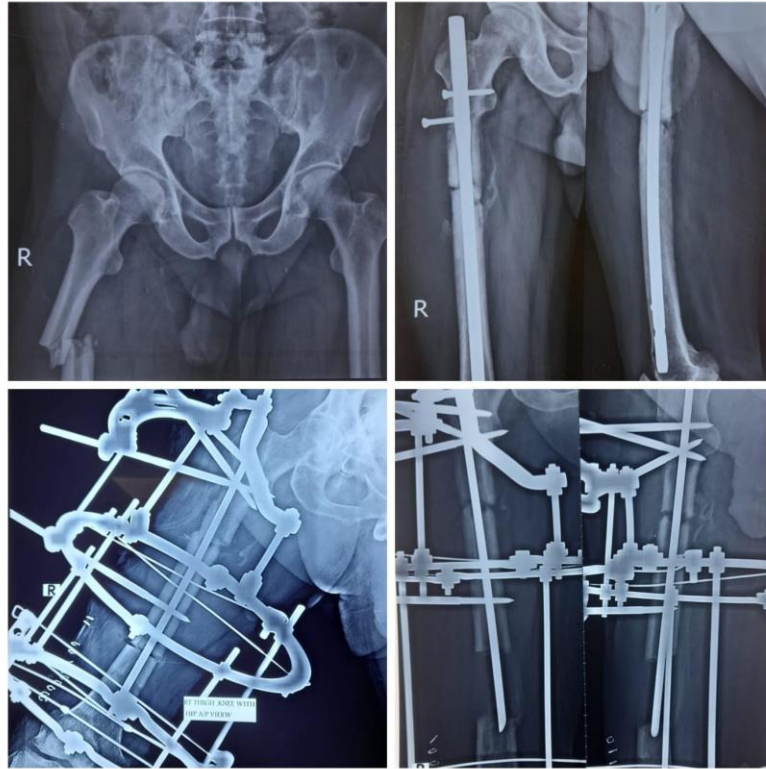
Radiographs of a 60 years old male patient showing femoral fracture before operation, after Rush nail application and Ilizarov frame construction
